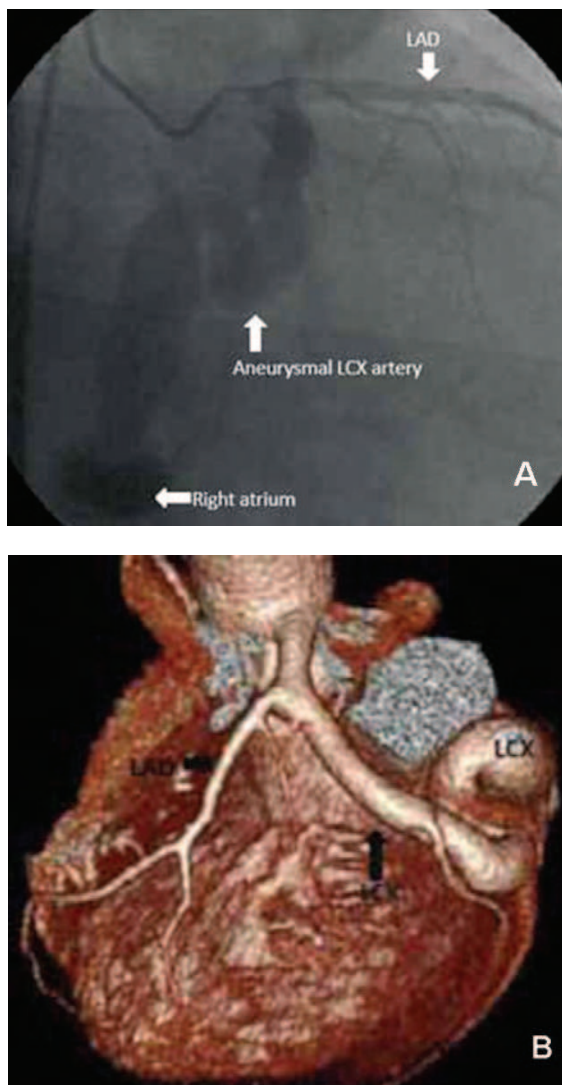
(A) Coronary angiogram showing a tortuous aneurysmal circumflex artery opacifying the right atrium. (B) Multislice cardiac-gated computed tomography scans showing the left anterior descending artery and a giant circumflex aneurysm with a very tortuous course terminating in a large fistulous connection into the coronary sinus (Pala et al, 2011). LAD: Left anterior descending artery; LCx: Left circumflex artery.
